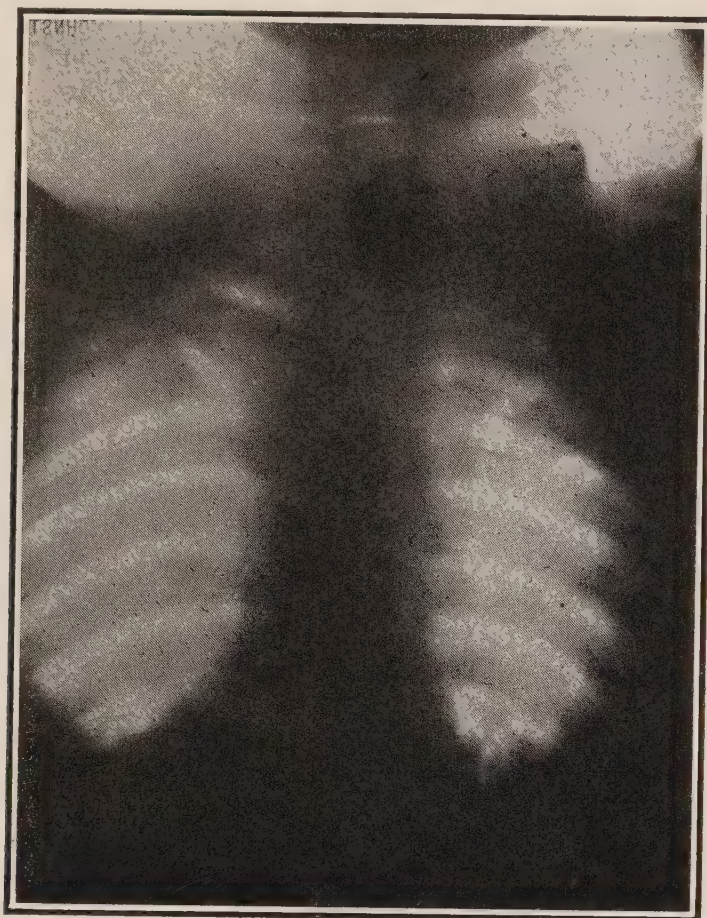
Radiograph showing bismuth-filled pulsion diverticulum in a man 67 years of age. Diverticulum (Fig. 255) removed by Dr. Otto C. Gaub by the Gaub-Jackson operation, Fig. 256. (*Radiograph made by Pancoast.*)
